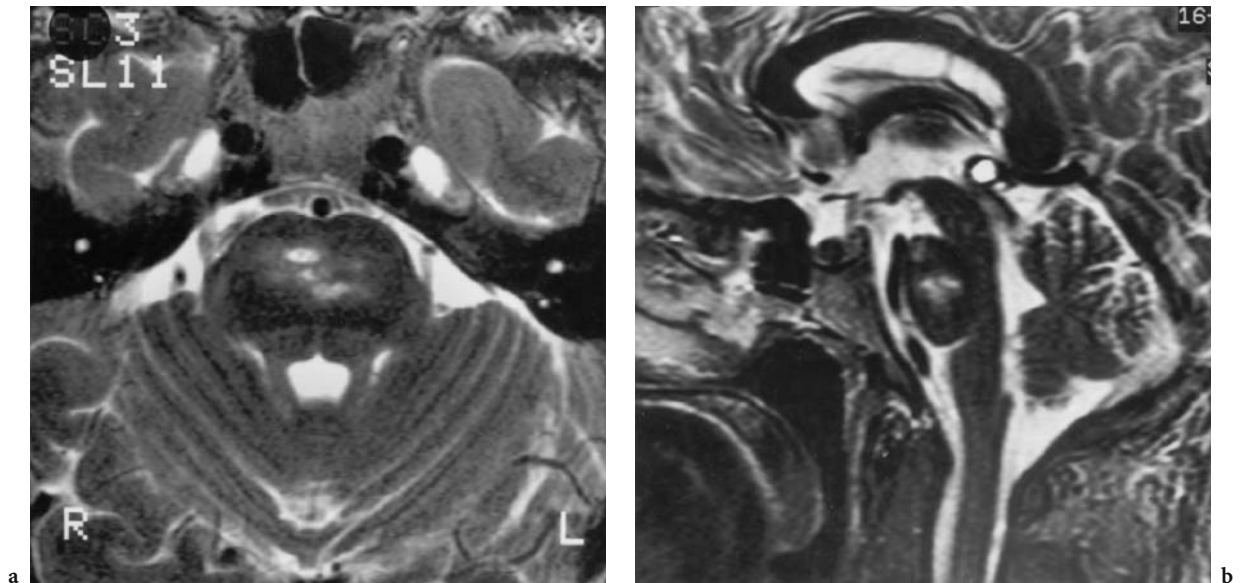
A 40-year-old man with brainstem symptoms and known Behçet's disease (same patient as in Fig. 6.23, 4 years later). Diagnosis: brainstem infarction developed in the course of Behçet' disease. T2-weighted MRI: axial (a) and midsagittal (b) views showing hyperintensities in the pons, corresponding to infarctions, secondary to the perivascular inflammation (additional pineal cyst without pathognomonic relevance). (From MÜLLER-FORELL and LIEB 1995)
